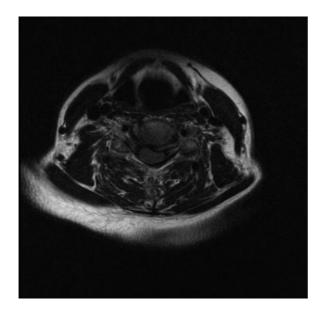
Preoperative T2-weighted axial magnetic resonance imaging demonstrating a left-sided disk herniation with resultant foraminal stenosis at C5–C6 impinging upon the left C6 nerve root.
